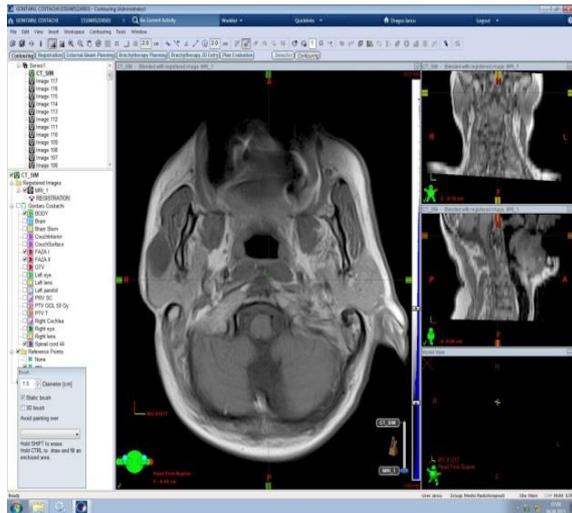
MRI scans of left parotid tumor before excision
